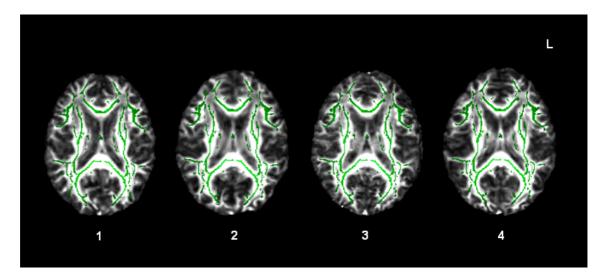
Alignment of the mean FA skeleton with individual patients' white matter tracts. The mean FA skeleton (thresholded at mean FA \geq 0.3, in green) overlaid on four patients' FNIRT-registered FA images: two patients (1 and 2) with normal T1 and T2* scans and two patients (3 and 4) with microbleed evidence of diffuse axonal injury on T2*-weighted MRI. MNI Z = 17 for all four images. L = Left.
